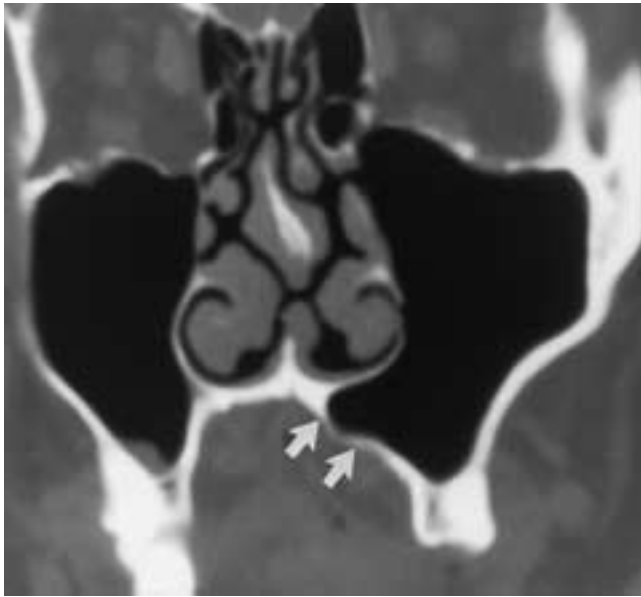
Asymmetric maxillary sinus pneumatization. Coronal CT scan obtained with bone window settings demonstrates extensive left maxillary sinus pneumatization. Extension to involve the hard palate has produced a mass effect and depression of the palate on the left (*arrows*), which are responsible for the asymmetry palpated by the patient's dentist.
